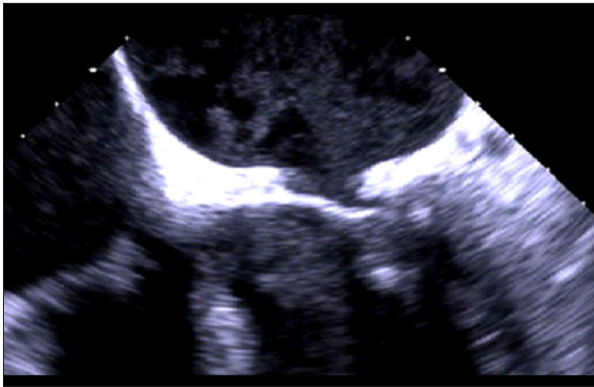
Preoperative transesophageal echocardiogram (TEE) showing mitral valve vegetation in a 43-year-old man with a history of systemic lupus erythematosus (SLE) who presented with endocarditis associated with Q fever due to infection with *Coxiella burnetii*. The TEE was performed in 2018 and shows impaired closure of the mitral valve leaflets (malcoaptation) associated with valve vegetation.
